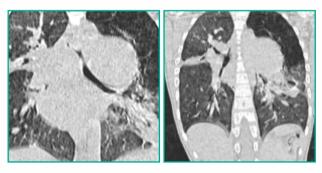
CT chest coronal plane showed obstruction of right middle and lower bronchi and left main bronchus partially obstructed.
